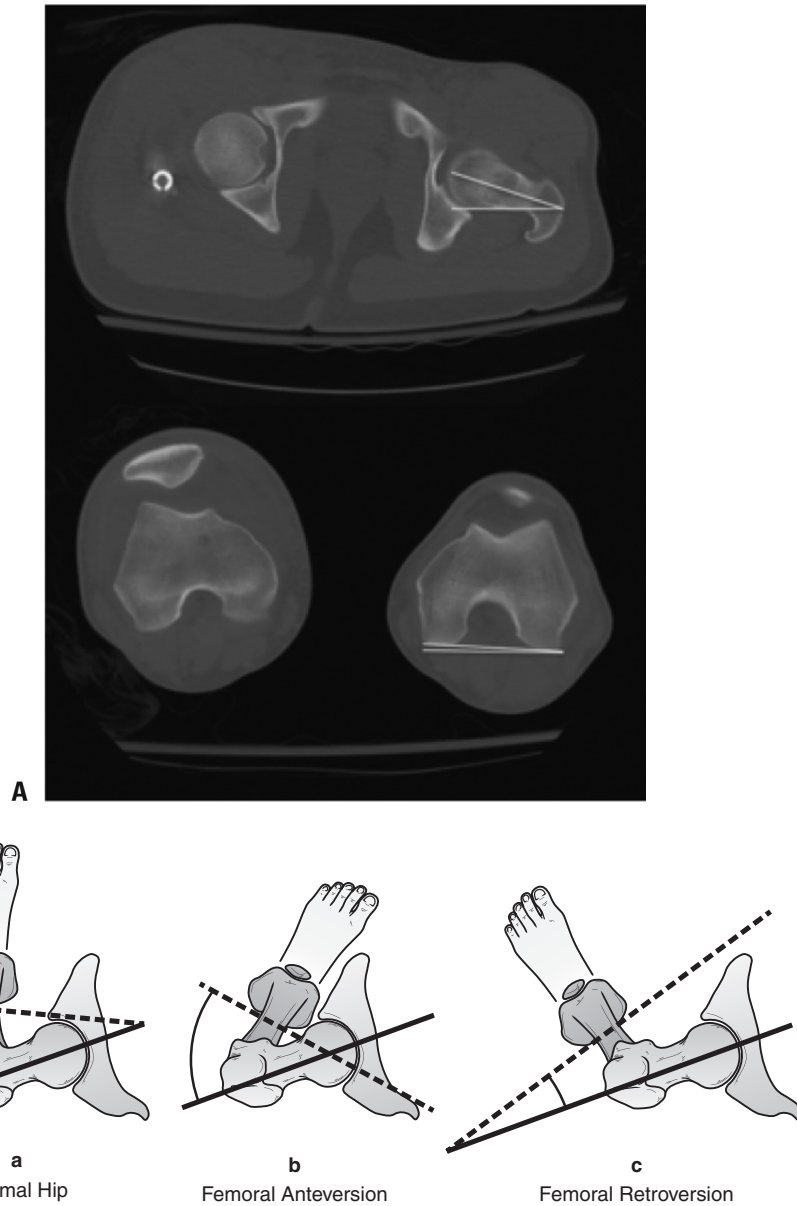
Femoral version. (A) Femoral version is defined as the angular difference between the femoral neck axis and the transcondylar axis of the knee. It is measured by superimposing axial CT cuts of both the femoral neck and the transcondylar axis to calculate the angle between the two. (B) Femoral version describes the “twisting” between the femoral neck and the femoral condyles. It affects rotation of the distal leg.
